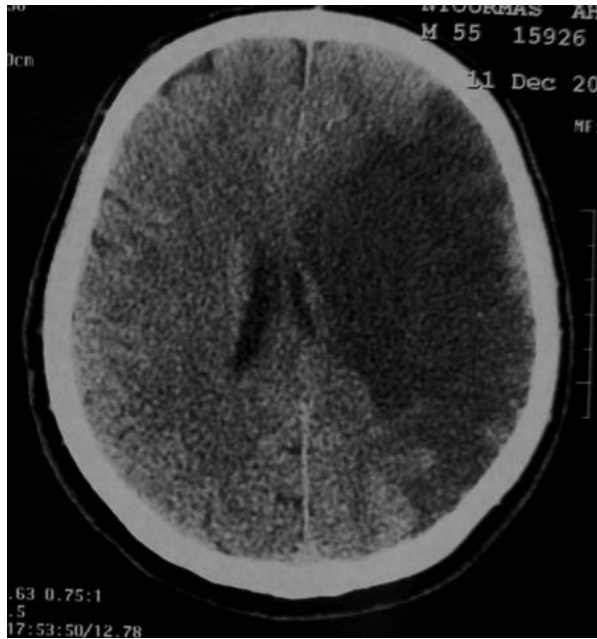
Samples of CT-scan.
